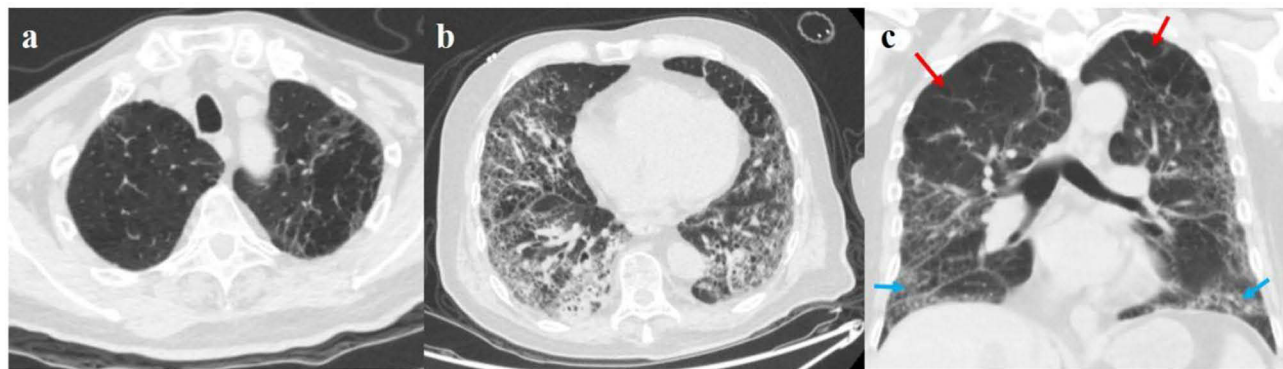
Chest CT on December 20, 2024. (a) Multiple round, thin-walled, translucent lesions in the upper lobes of both lungs; (b) Multiple patchy, cord-like, nodular and grid-like increased density shadows occur in the lower lobes of both lungs. (c) Multiple round, thin-walled, translucent lesions in the upper lobes of both lungs (red arrow), Multiple patchy, cord-like, nodular and grid-like increased density shadows occur in the lower lobes of both lungs (blue arrow).
